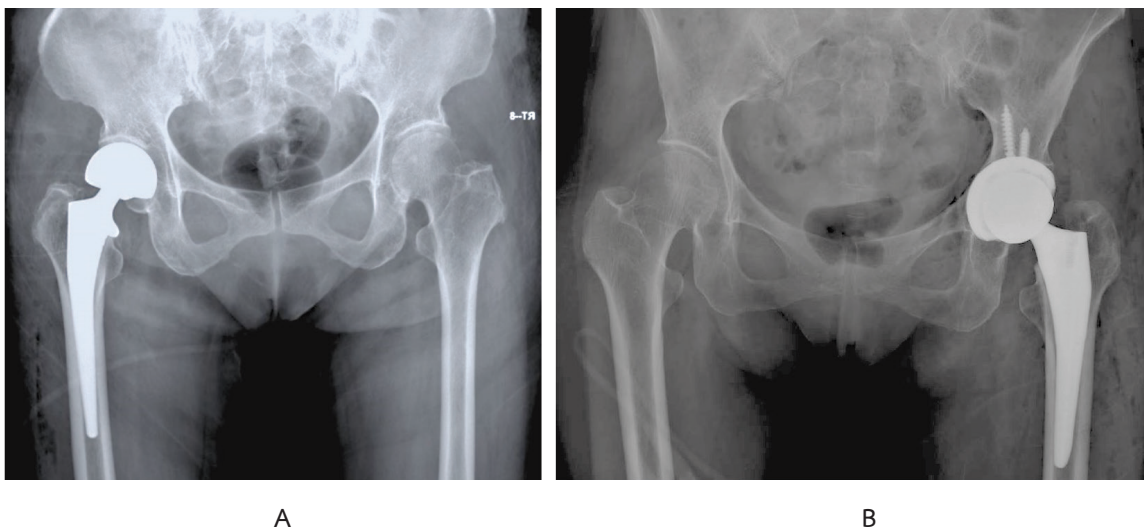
Plain radiographs show A. Bipolar hemiarthroplasty. B Total hip arthroplasty.
